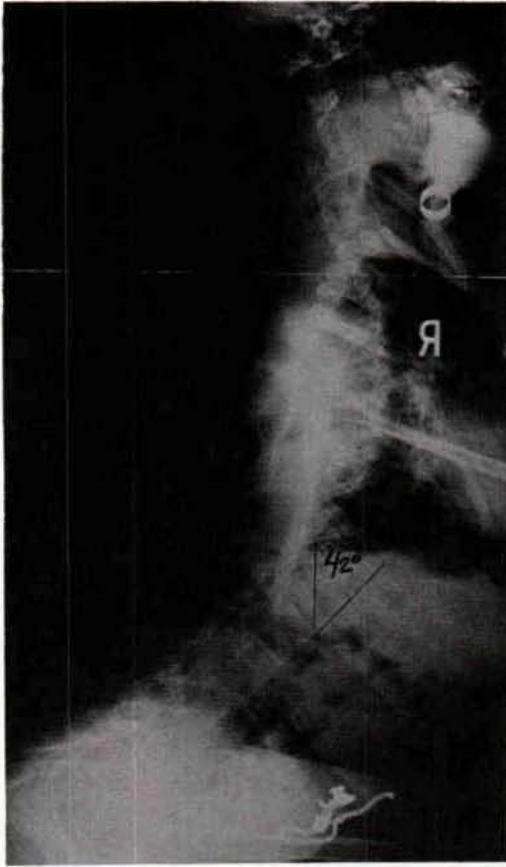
Lateral X-ray of a patient with advanced Duchenne Muscular Dystrophy. Even this poor belly-on-thigh posture required the two-handed support of his mother anteriorly.
